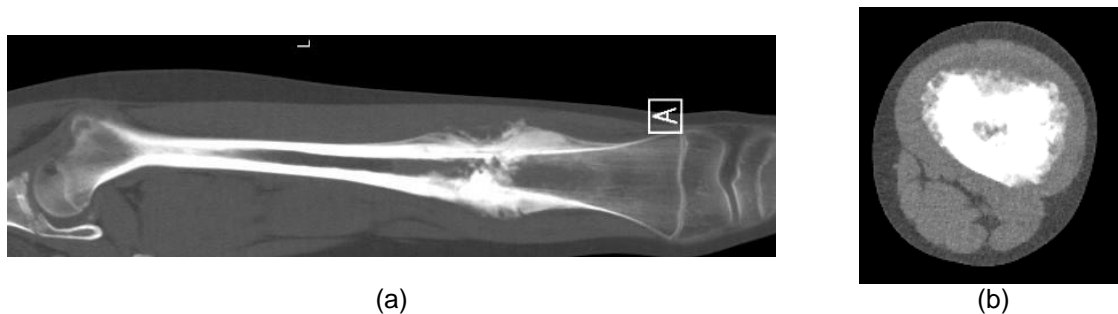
Radiological appearance of Osteosarcoma with soft tissue components in the distal femur shown an (a) transversal and (b) axial view on CT
